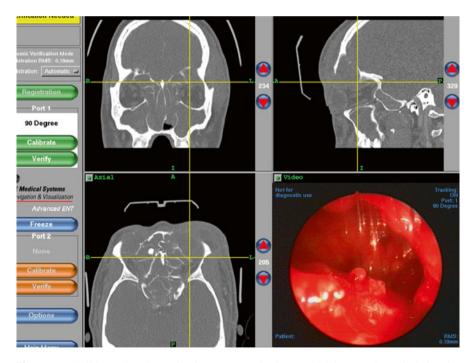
Triplanar CT image guidance and endoscopic view of the sphenoid sinus after removal of extensive allergic fungal mucin. Note the large dehiscence in the posterior sphenoid over the brain stem
